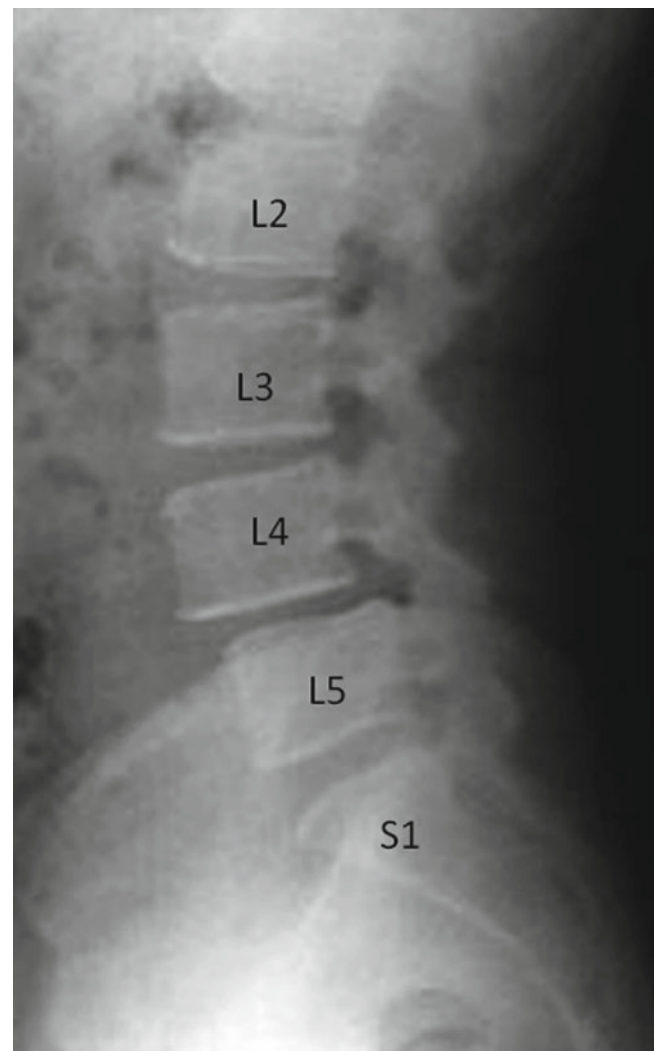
Lateral lumbar plain radiograph demonstrating a degenerative spondylolisthesis at L4–5, where the L4 vertebral body is located slightly anterior to the L5 vertebral body. There is also multilevel lumbar disc collapse, most significant at L4–5
